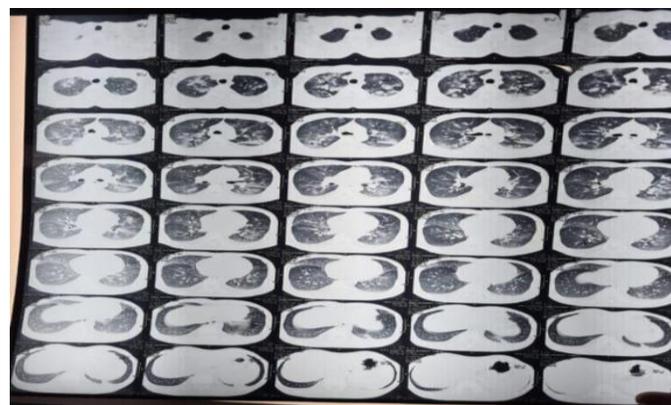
CT chest shows multifocal peribronchial ground glass opacities with CORADS-4
